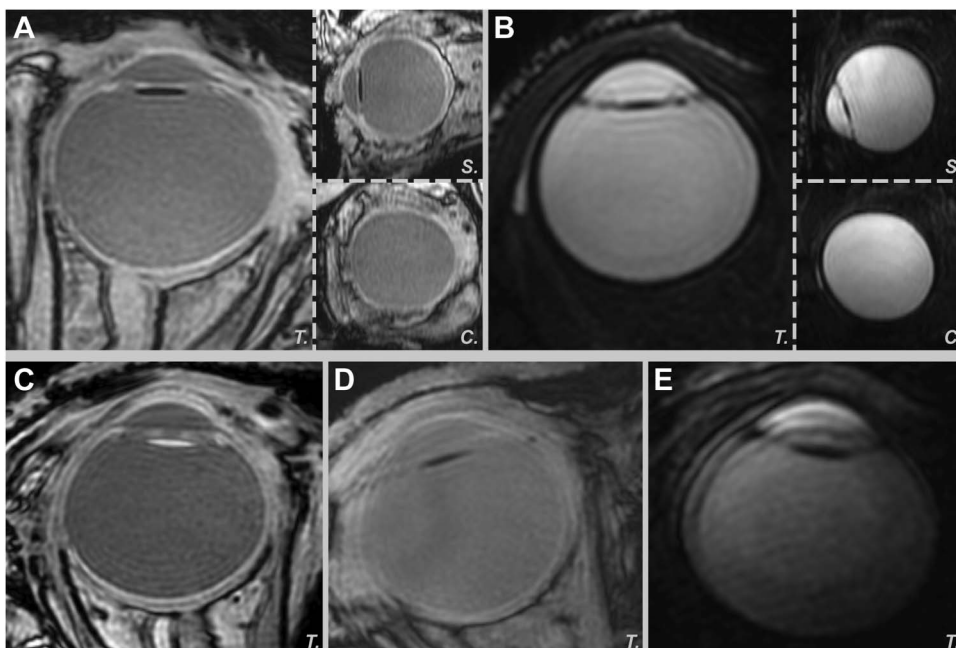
Examples of high-resolution 3D MRI scans. A: A 3DT1 scan with normal quality in transversal (T.) view, showing a hypointense IOL. The sagittal (S.) and coronal (C.) reconstructions are also shown. B: A 3DT2 scan with normal quality. C: A 3DT1 scan with normal quality and a hyperintense, hydrophilic, IOL. D: A 3DT1 scan with mild motion artifacts that required manual correction of the segmentation. E: A 3DT2 scan with movement artifacts that required the use of a scan with a slightly lower resolution that did not have cued-blinking motion control.
